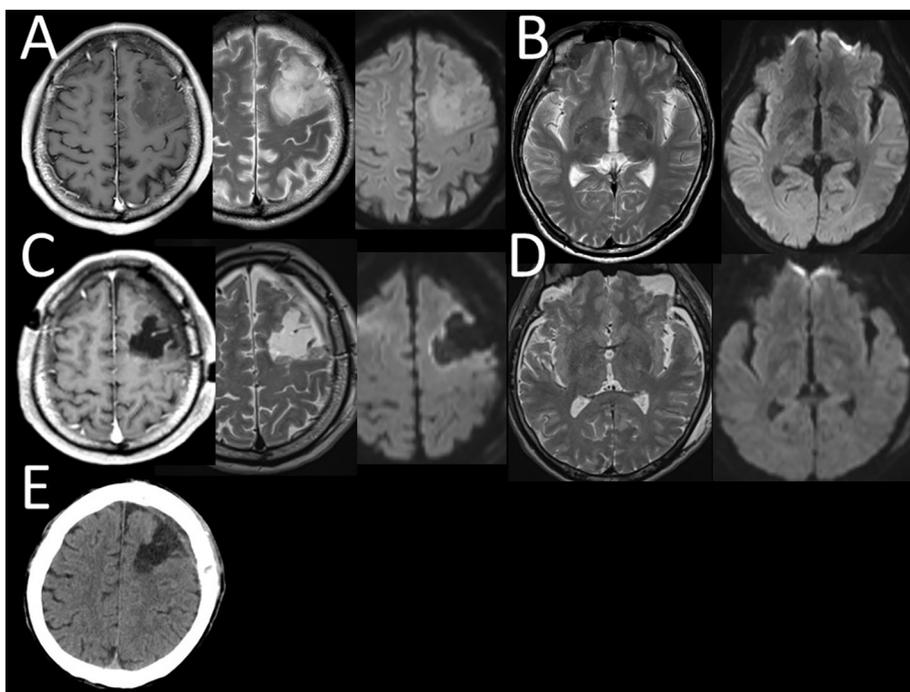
A 60-year-old man with oligodendroglioma. Magnetic resonance imaging (MRI) before the surgery showed that the tumor was located in the left supplementary motor area (A: axial imaging at high convexity level. Left; T1WI with gadolinium [Gd] administration, middle; T2-weighted imaging [WI], right; diffusion-weighted imaging [DWI] and B: axial imaging at low convexity level. Left; T2WI, right; DWI). MRI at postoperative day (POD) 1 shows the tumor cavity after removal without massive hemorrhage or infarction (C: axial imaging at high convexity level. Left; T1WI with Gd, middle; T2WI, right; DWI and D: axial imaging at low convexity level. Left; T2WI, right; DWI). Although the patient had disturbance of consciousness and transient aphasia on POD 9, computed tomography (CT) showed no new lesions (E).
